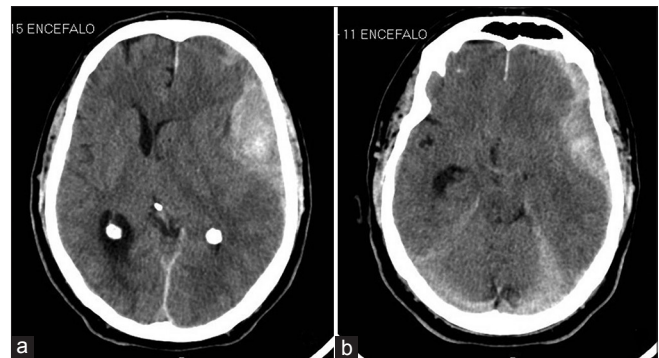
CT scan on admission showing an acute subdural hematoma extending from the left frontal lobe to the left temporal lobe (a, b)
